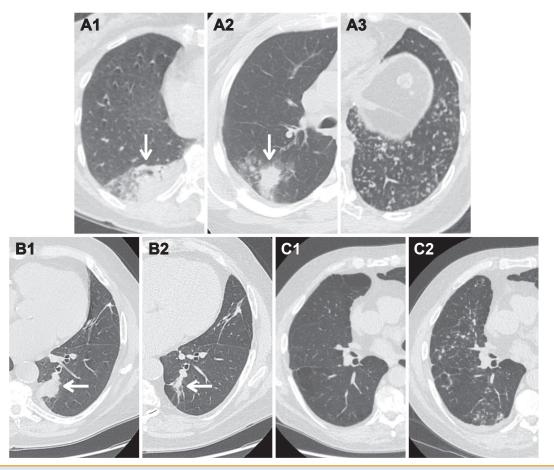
Infectious or inflammatory findings. (A) Findings at lung cancer screening (LCS) that suggest an infectious or inflammatory process include new segmental or lobar consolidation (A1, arrow), large new nodules (≥8 mm) appearing within a short interval (A2, arrow), or multiple new nodules (A3). Such findings may be classified as Lung CT Screening Reporting and Data System (Lung-RADS) 0 based on clinical suspicion of an infectious or inflammatory process with a recommendation for follow-up low-dose CT (LDCT) in 1 to 3 months to ensure resolution. The study is then reclassified at follow-up according to the most concerning finding. (B) A 55-year-old patient had a baseline LCS CT classified as Lung-RADS 3 (not shown) and presents for 6month follow-up LDCT. There is a new lobular 28-mm mean diameter soft tissue nodule in the left lower lobe (B1, arrow). Given the size and lack of an abnormality in this area on the prior examination, the study was classified as Lung-RADS 0 for a likely infectious process. The patient returned for follow-up LDCT at 3 months, which showed a marked decrease in size but not complete resolution (B2, arrow). No new findings were identified, and other nodules were stable. The examination was reclassified as Lung-RADS 2 with a management recommendation of a 12-month LCS CT from the date of the current study. Had the nodule remained stable, increased, or only slightly decreased in size, an infectious or inflammatory process would be less likely; the examination would be reclassified as Lung-RADS 4B based on size and composition with a recommendation for diagnostic evaluation. (C) A 61-year-old patient presenting for annual LCS CT is found to have multiple new tree-in-bud nodules bilaterally with a basilar predominance (C2) relative to the prior annual LCS examination (C1). Although an infectious process is most likely, a Lung-RADS 0 classification with 1- to 3-month follow-up LDCT is unnecessary. In this case, the examination may be classified based on the size and composition of the new nodules (solid, < 4 mm), corresponding to Lung-RADS 2.
